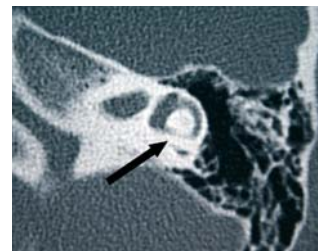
Patient 1; axial CT scan of the left lateral semicircular canal, ossification zone (arrow).
